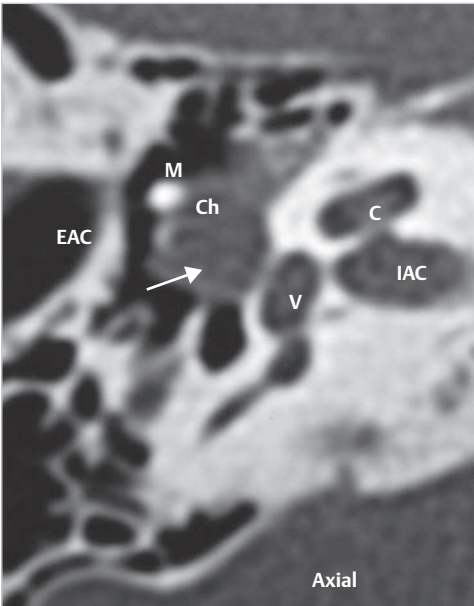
A case of congenital cholesteatoma in an 11-year-old child. On otoscopic examination, a whitish mass is seen in the tympanic cavity with transparency. The CT examination demonstrated that cholesteatoma (arrow) is localized mainly in the tympanic cavity, with small extension toward the attic. The incus is eroded, and continuity of the ossicular chain is impaired. C, cochlea; CA, carotid artery; Ch, cholesteatoma; EAC, external auditory canal; IAC, internal auditory canal; M, malleus; V, vestibule.
